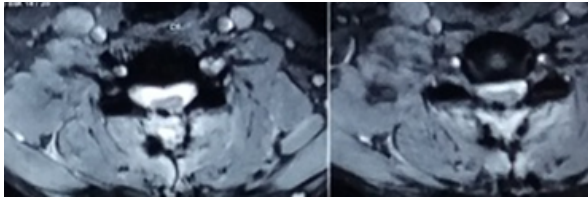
Post-operative – MRI T 2 Axial images with no residual lesion
